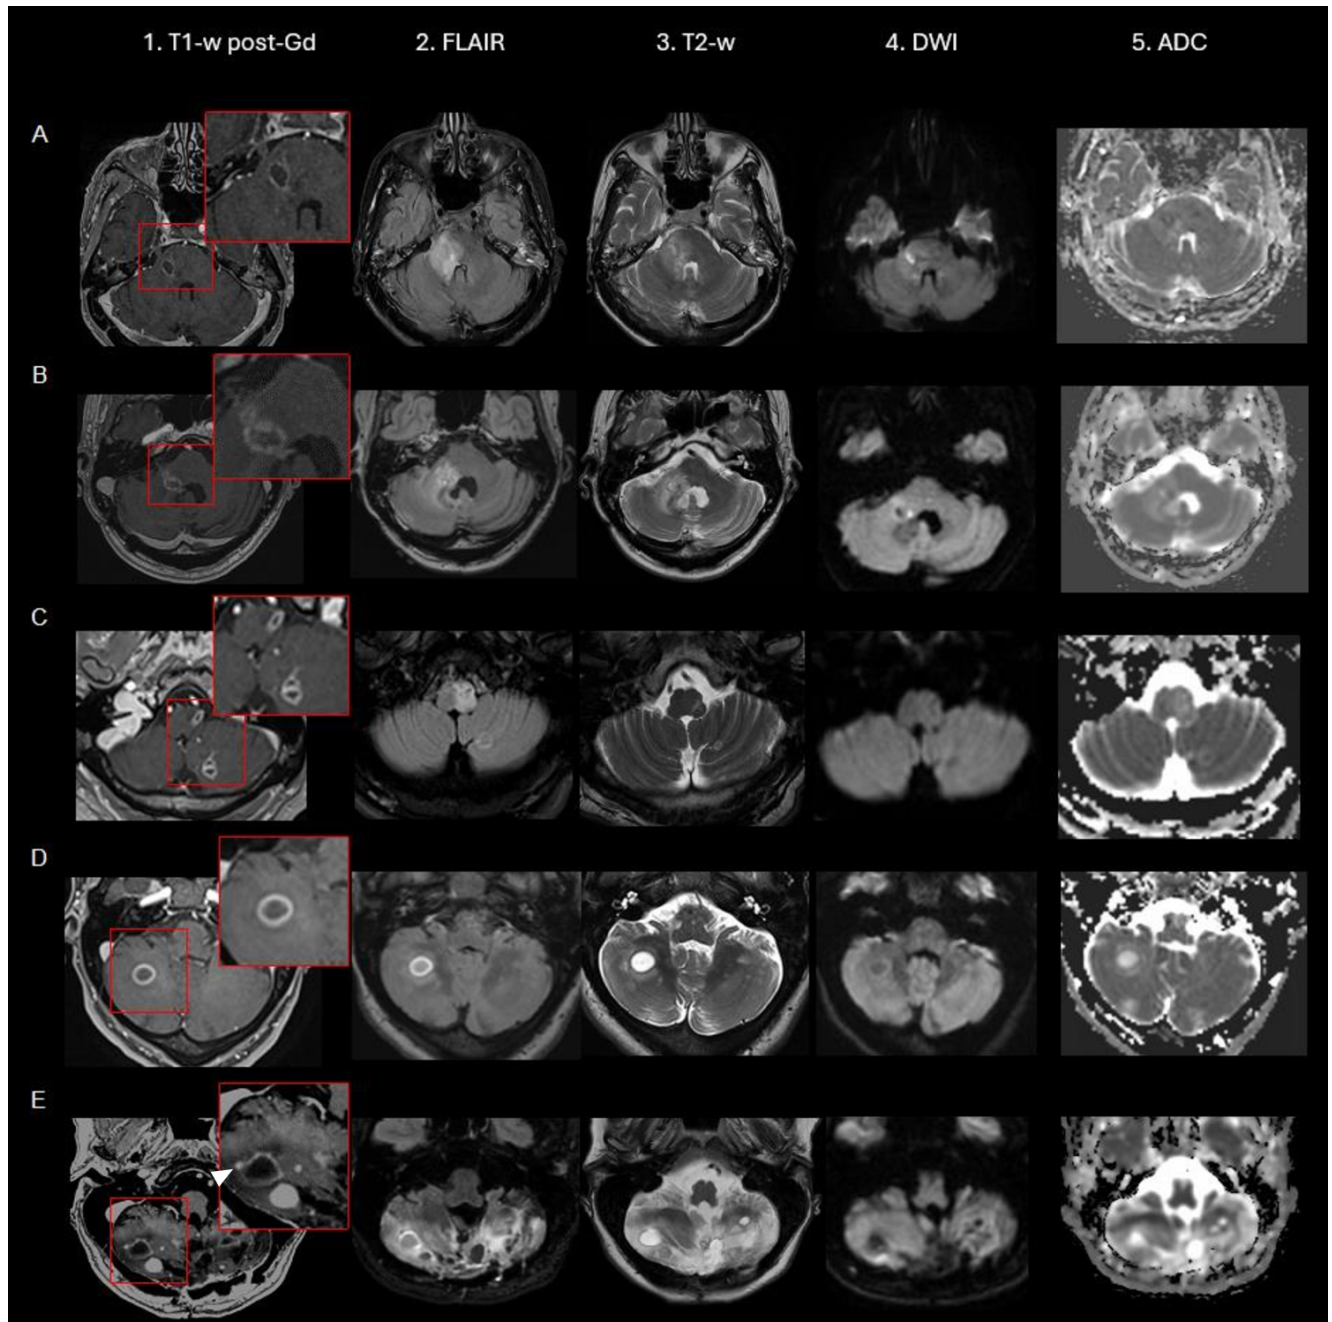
Brain MRI of representative PFREL cases from our institutional case series. Clinical cases corresponding to A) Richter's syndrome, B) radionecrosis, C) subacute ischemic stroke, D) multiple sclerosis, and E) hemangioblastoma (mural nodule, arrowhead). *Abbreviations:* T1-w post-Gd, T1-weighted post-gadolinium injection; FLAIR, fluid attenuated inversion recovery; T2-w, T2-weighted; DWI, diffusion weighted image; ADC, apparent diffusion coefficient.
